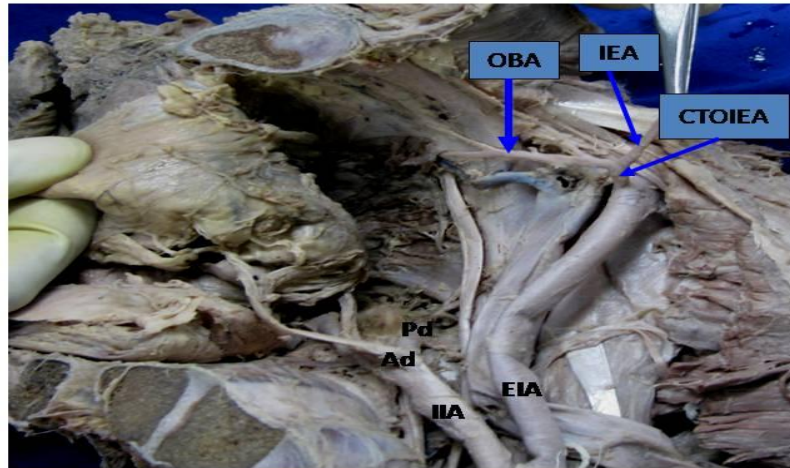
right sided pelvis shows origin of obturator artery from a common trunk (CT), which also gives origin of inferior epigastric artery (IEA). (OBA- Obturator artery, Ad- Anterior division, Pd- Posterior division of IIA- internal Iliac Artery).
